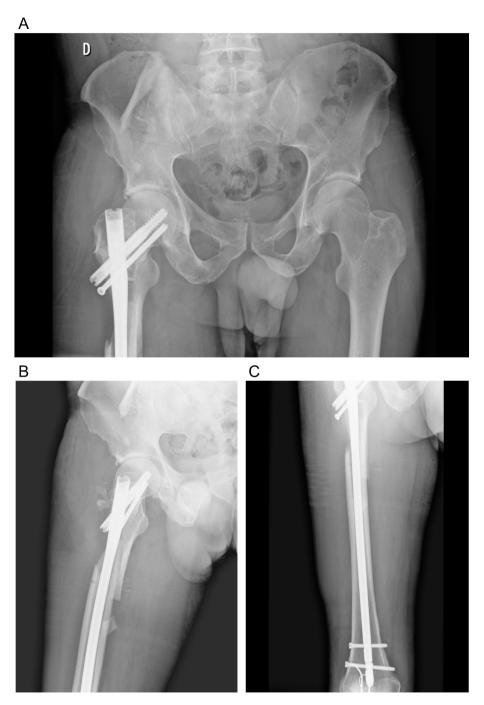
A, B and C – Pelvis and right femur radiographs at admission. The femoral fracture had been fixed with a long nail, but it is obvious the critical cortical defect of the proximal femur. It is noticeable a bone fragment overlaying the right iliac wing.
